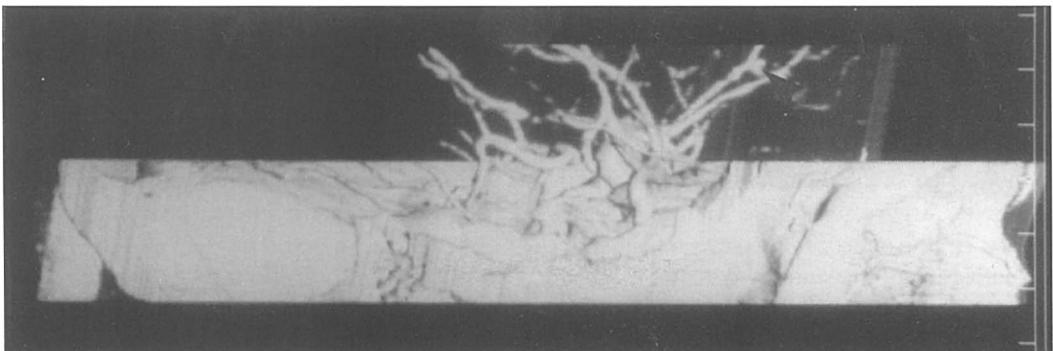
This small aneurysm at the bifurcation of the callosomarginal and pericallosal arteries on the right side was missed on CTA images because of its small size and unusual position (arrow).
